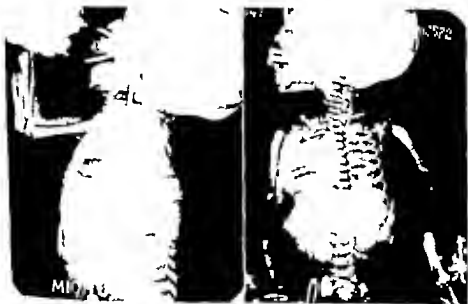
(Case I H) — 1. Roentgenogram taken the day following operation demonstrating the intrathoracic stomach. 2. Oblique view on the fifth postoperative day certifies the position of the air-filled stomach.
